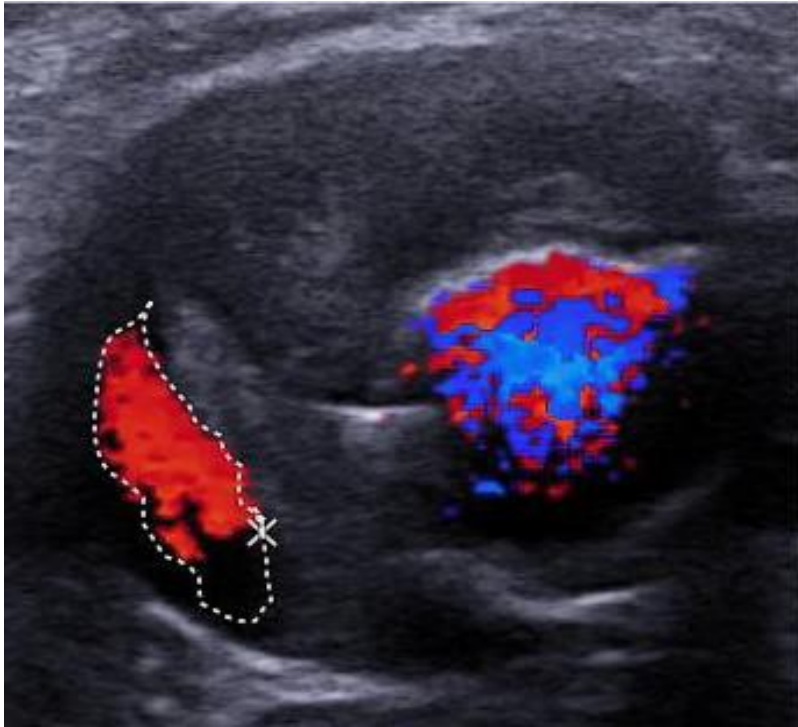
Transverse acquisition of Doppler Ultrasound at the same level than CT scan (Figure 4a).
